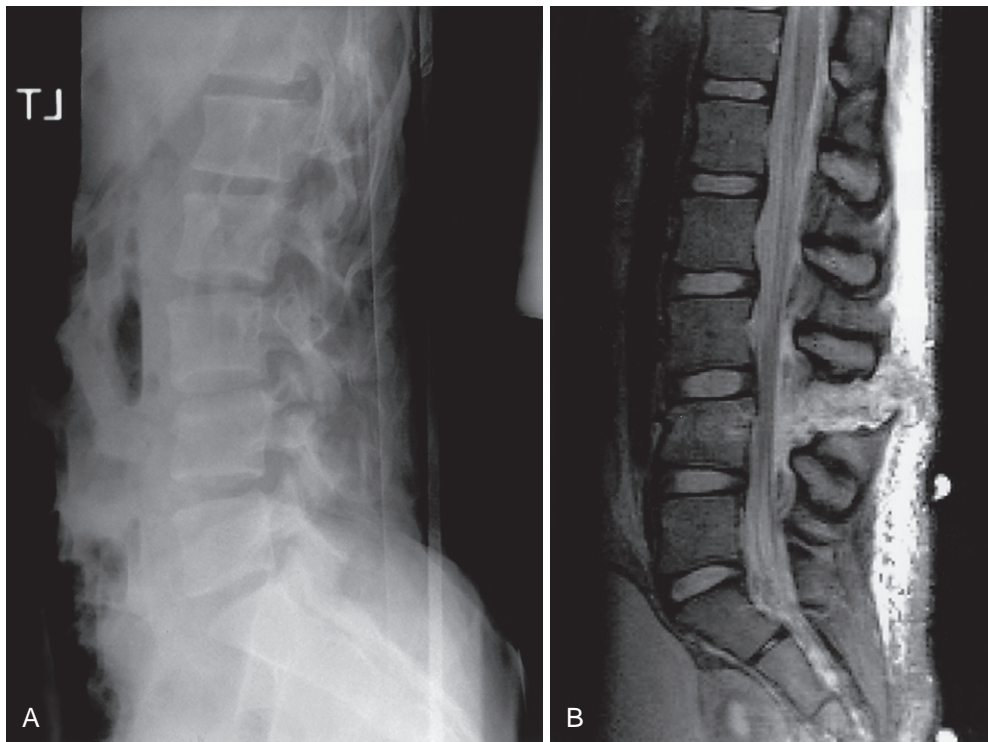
Lap-belt injury of L4 in a 15-year-old girl without neurologic injury. A, Lateral lumbar spine radiograph shows fracture of both the L4 body and the posterior spine. B, Sagittal magnetic resonance image of the lumbar spine shows the extensive bony and soft tissue injury.
